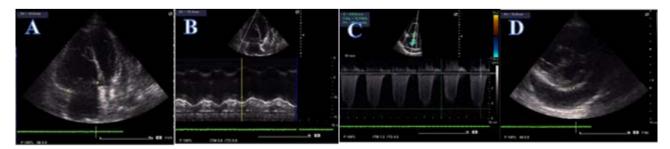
Trans thoracic cardiac Doppler ultrasound ((A) right ventricular dilation, (B) altered RV TAPSE, (C) presence of PAH, (D) profuse pericardial effusion).
